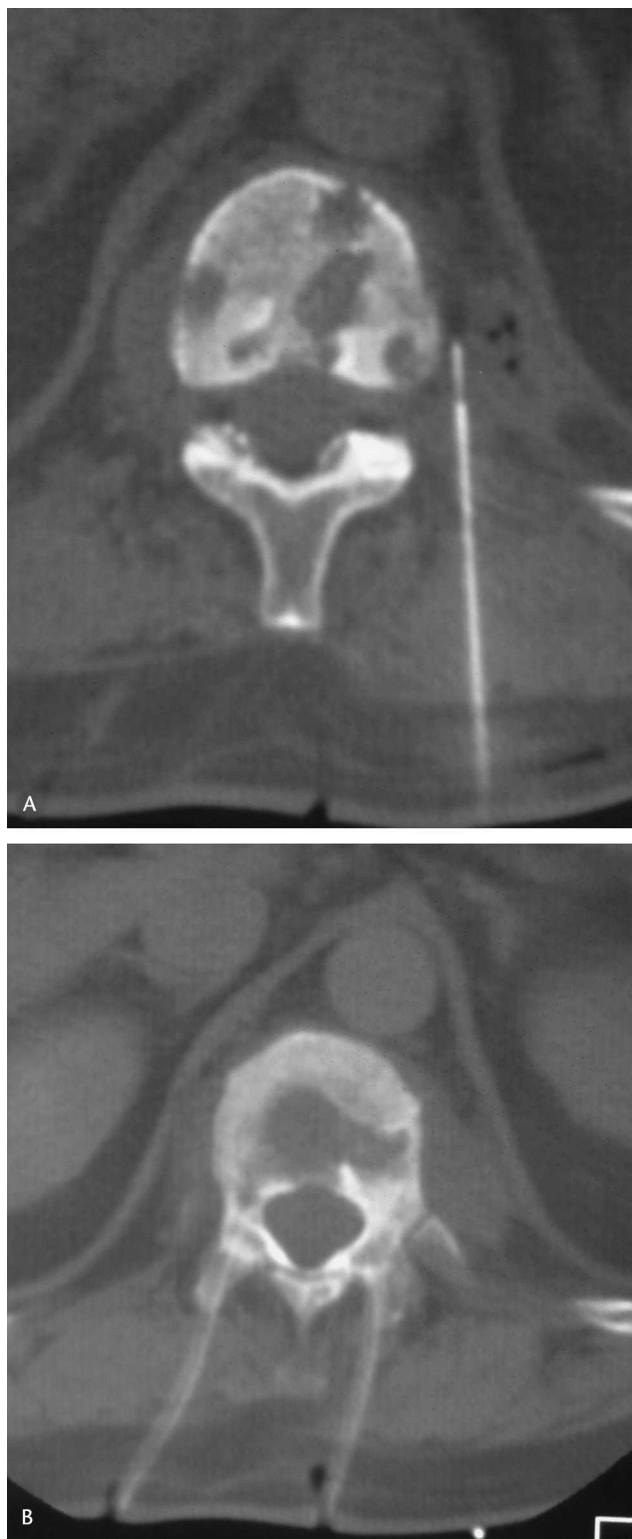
(A) Percutaneous computed tomography (CT)-guided drainage of paraspinal abscess is shown. (B) Bilateral percutaneous transpedicle drainage tubes placed after transpedicle discectomy for suction–irrigation with antibiotics is shown.
